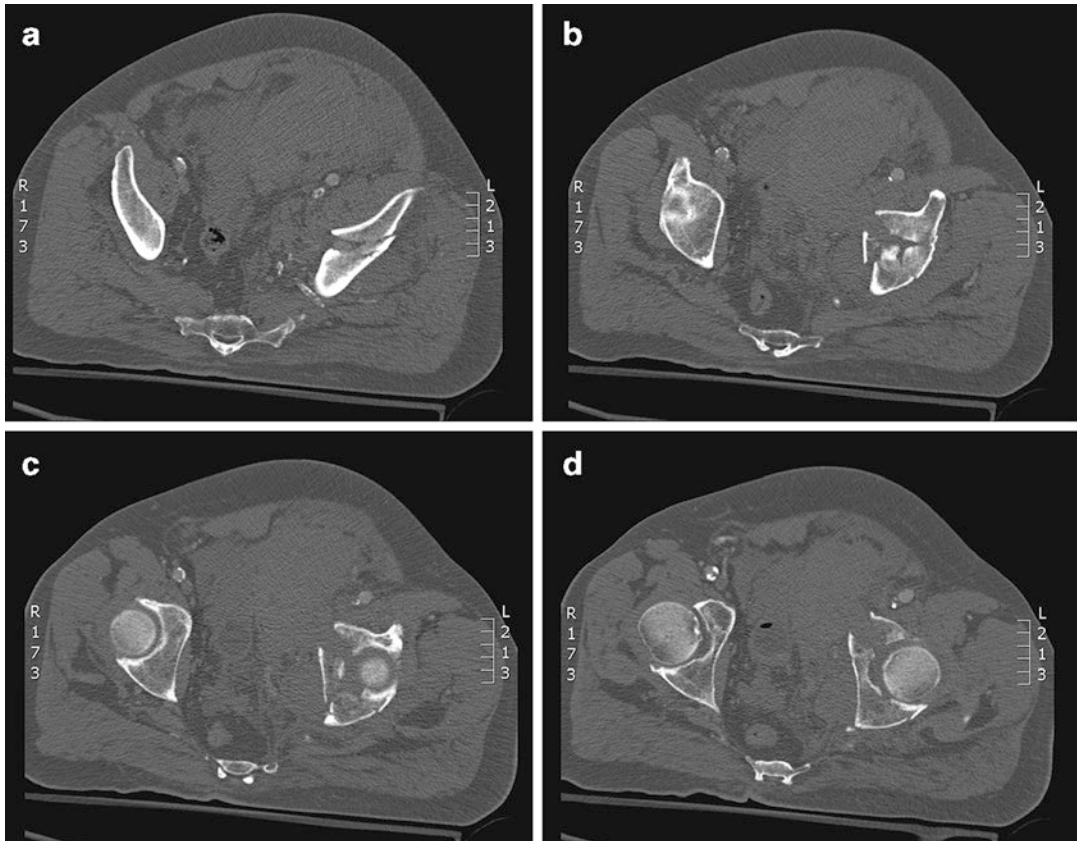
(a–d) Axial CT pelvis
